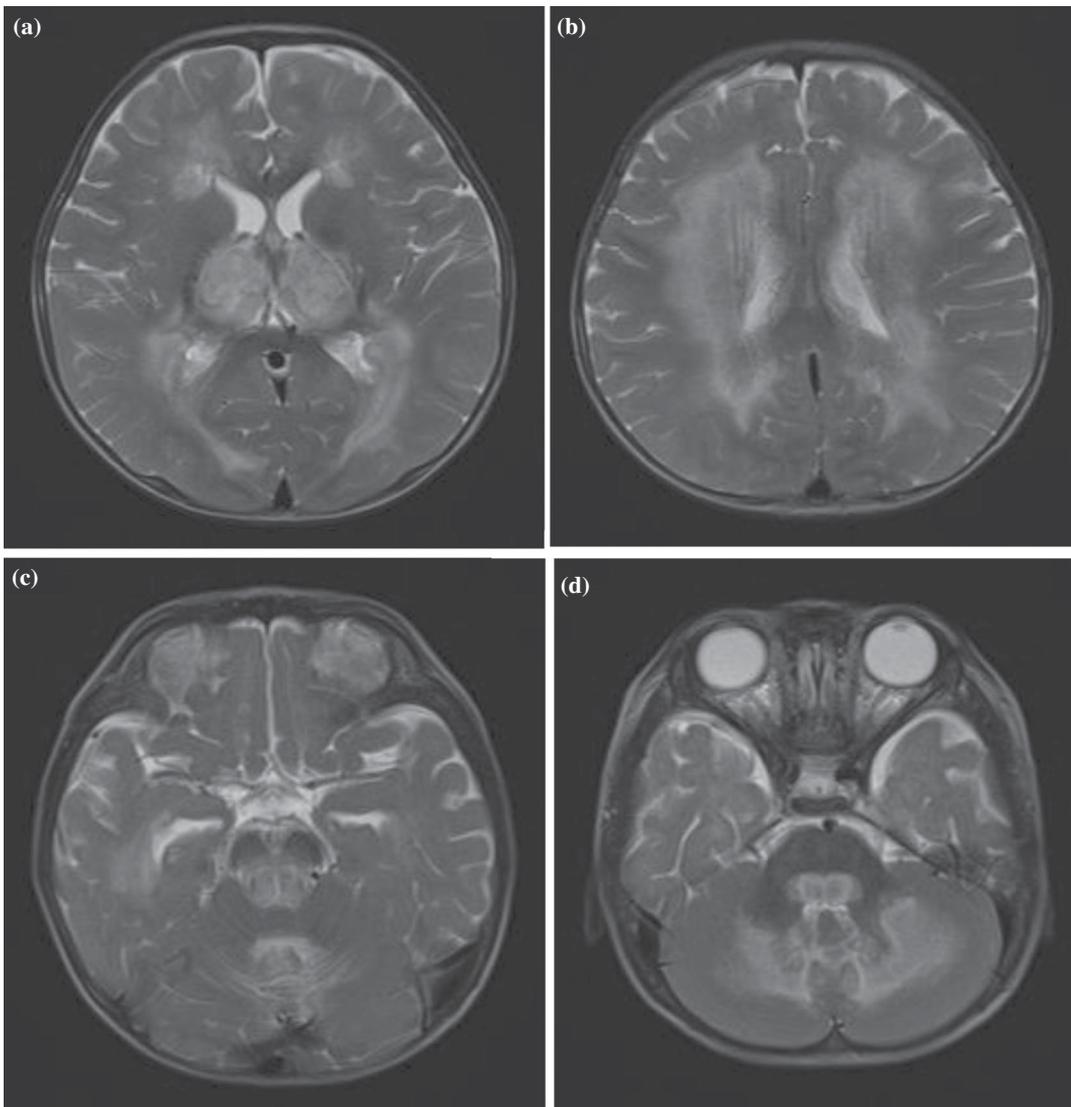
MRI of case 2 showing symmetric multifocal lesions at bilateral thalami with a whorl-like pattern (a), periventricular white matter (b), brain stem (c) and cerebellum (d).
